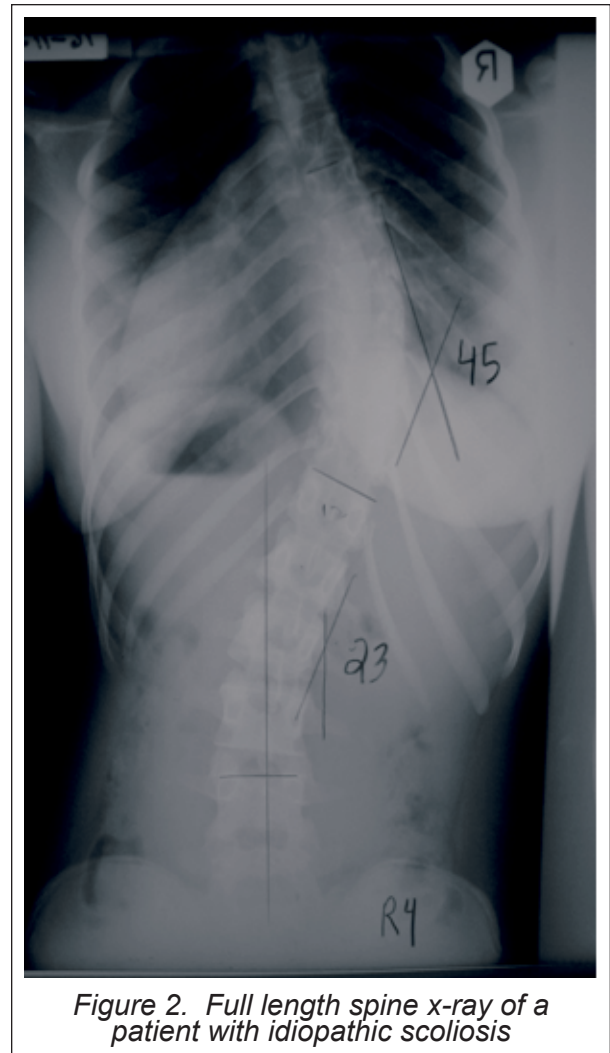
Full length spine x-ray of a patient with idiopathic scoliosis
